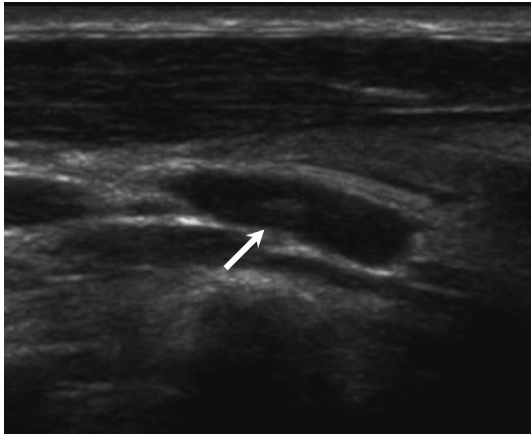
Intraoperative ultrasound findings in a patient with negative technetium-99m sestamibi scintigraphy scans. This patient (No. 2, Table 2) had multiglandular disease, but the neurogenic tumor near the thyroid was misdiagnosed as SA.
